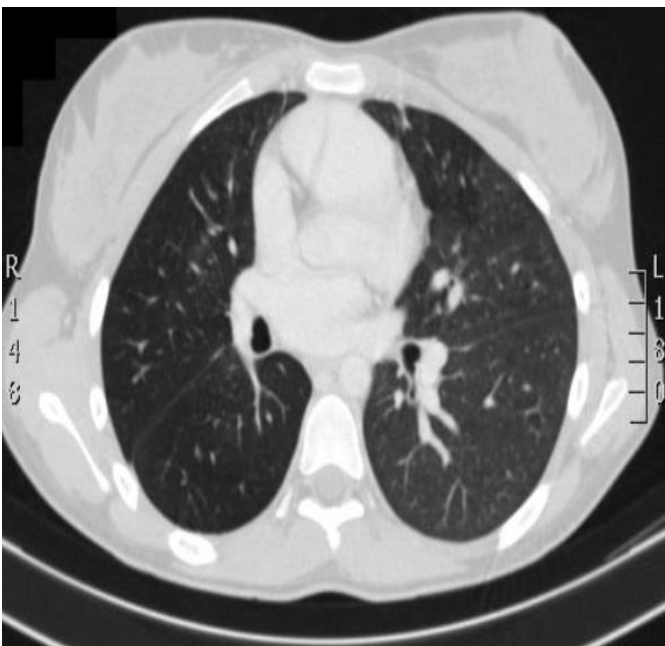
Axial CT image shows right hyperlucent lung with diminished vascularity on right side
